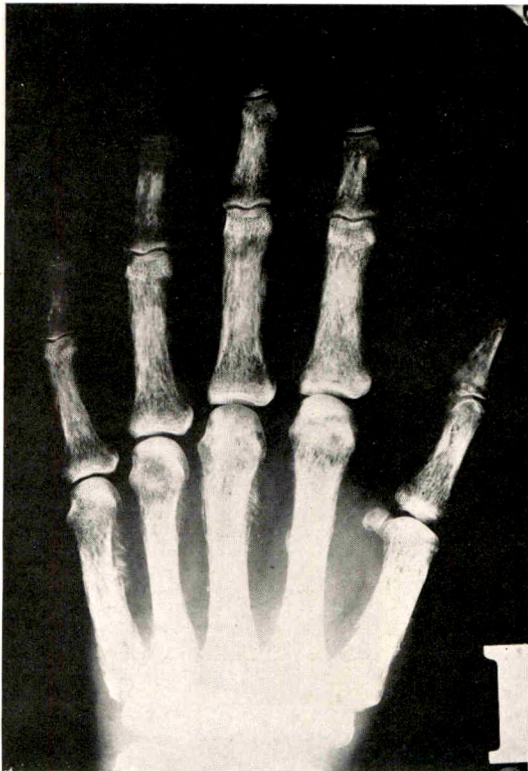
Roentgenogram of right hand.
